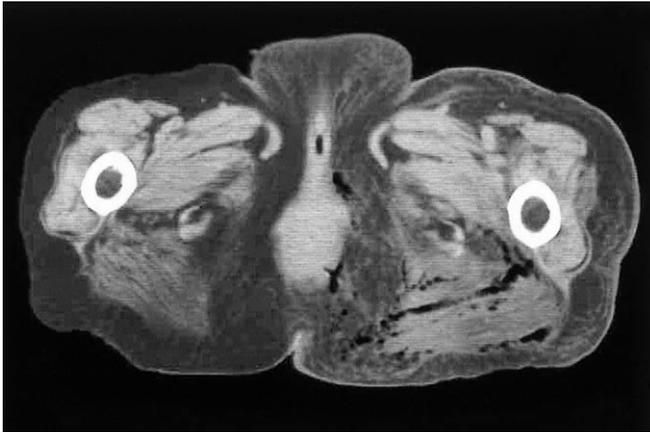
Case 1. Pelvic computed tomography revealed a gas shadow along the deep fascia of the hip and thigh just near the femoral bone.
